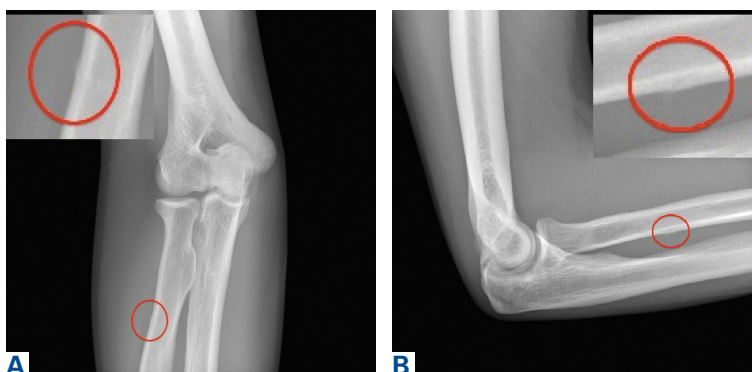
Red circle on (A) oblique and (B) lateral radiographs of the right elbow shows the location of the stress fracture.
